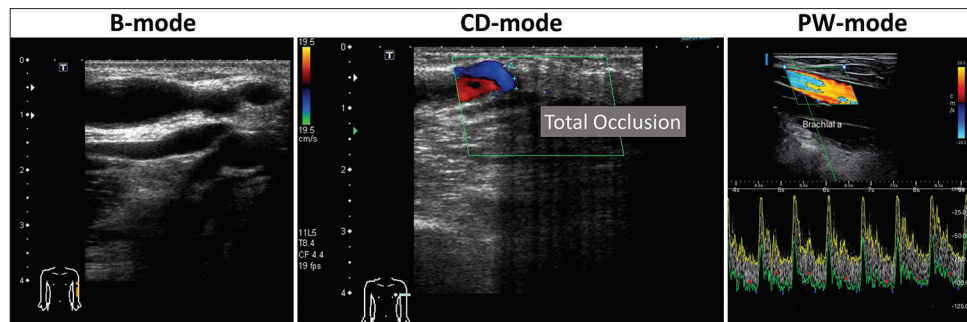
B-mode can be used to depict the diameter and depth, or morphological lesions (e.g. stenosis, thrombosis...) of the arteriovenous fistula vessels. CD-mode can be used to detect the blood flow. PW-mode allows the measurement of blood flow velocity, waveform, and volume. B-mode: Brightness mode, CD-mode: Color Doppler mode, PW-mode: Pulse Wave mode
